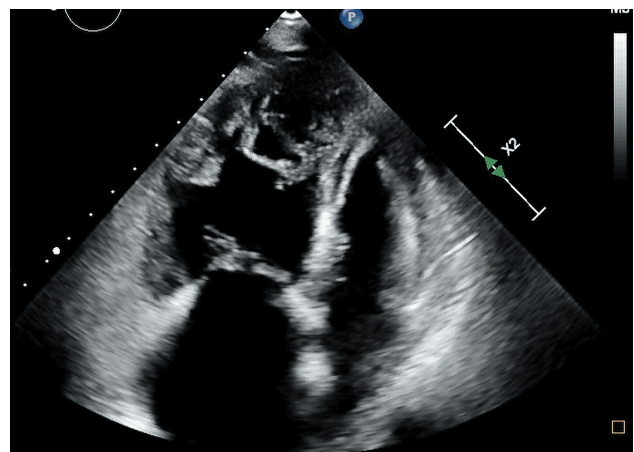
Cardiac ultrasound: dilation of the right heart, with a high probability of PH. PH, pulmonary hypertension.
